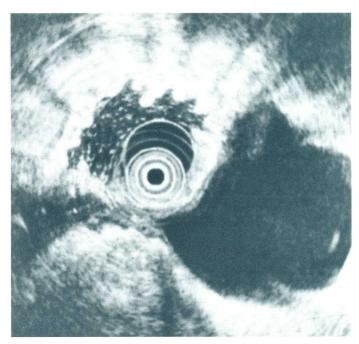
Endosonographic image from the gastric corpus showing a large, almost completely anechoic pseudocyst (between 2 and 5 o'clock). The cyst can be endoscopically drained as the distance to the stomach is small and no vessels are visible in between.
